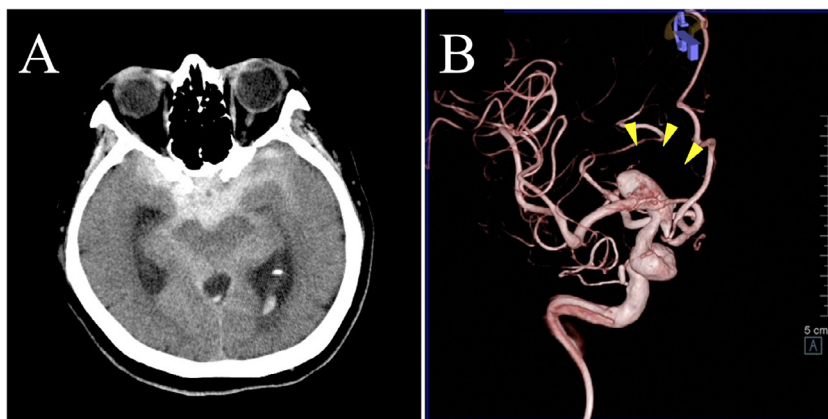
Head CT on admission revealed a subarachnoid hemorrhage (A) due to rupture of cerebral aneurysm (B).
